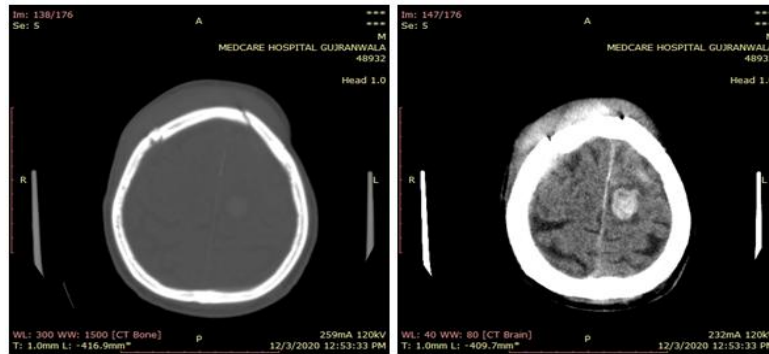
75 Years, Male, CT BRAIN, H/O RTA
